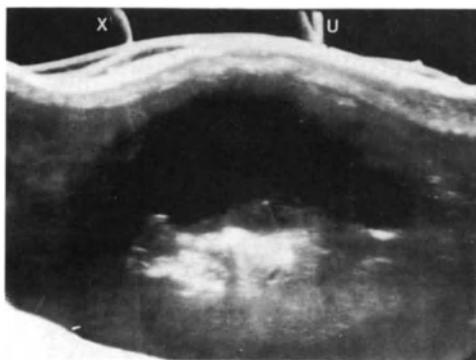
Ultrasound sagittal section showing large abdominal aortic aneurysm.
